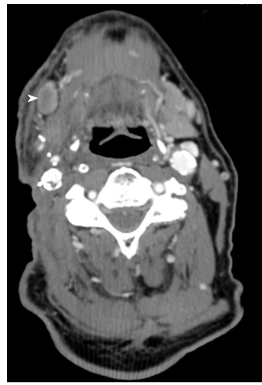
Contrast-enhanced computed tomography scan of neck prior to erlotinib treatment. Development of right neck focal skin irregularity and right submandibular lymphadenopathy (white arrowhead) consistent with metastases were noted.
